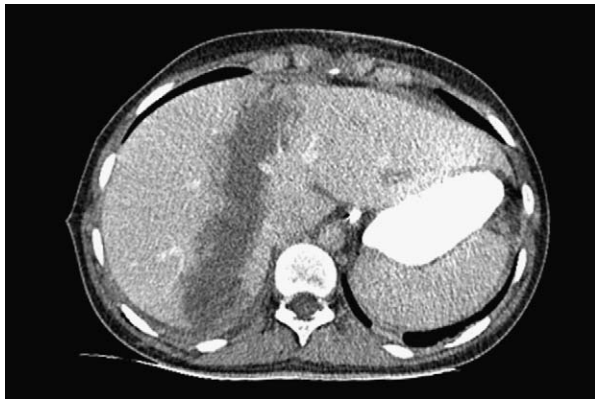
CT image of the gunshot injury to liver segments IVa, VII and VIII at the day of trauma.
